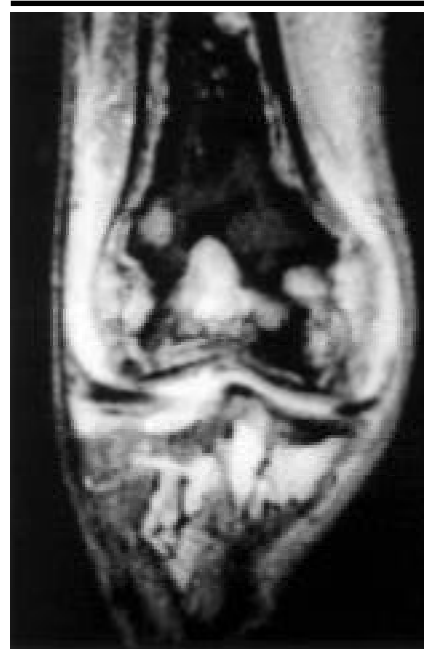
MRI of the knee on T2-weighted images showing findings compatible with osteomyelitis of the femur and tibia.
